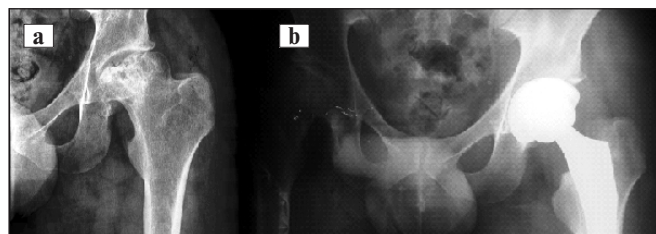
X-ray images of the left hip joint before (a) and after (b) total hip arthroplasty
